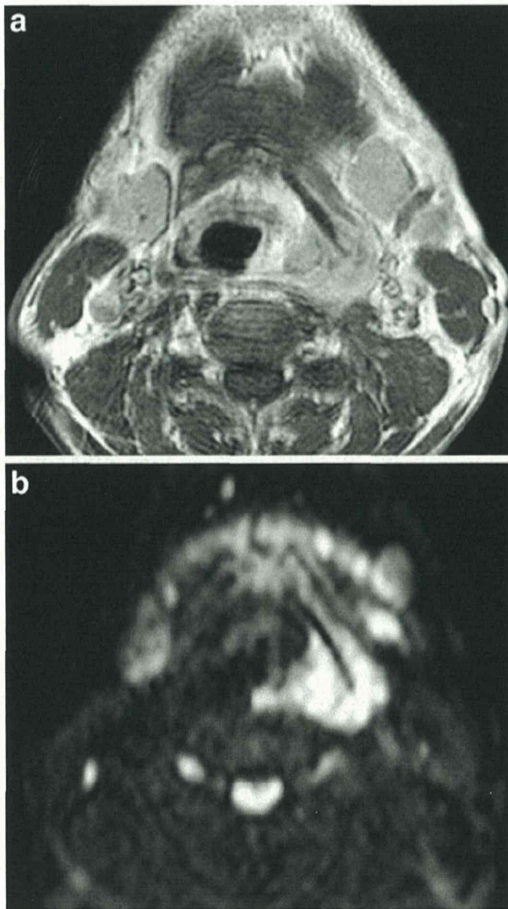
A representative poor-prognosis man in his 50s (local and regional failure at 3.3 months follow-up and died at 13.1 months follow-up) with hypopharyngeal cancer (T4N2M0, performance status 0, ADC 0–200 = $1.65 \times 10^{-3} \text{ mm}^2/\text{s}$, ADC 300–1,000 = $0.90 \times 10^{-3} \text{ mm}^2/\text{s}$). a Gadolinium-enhanced T1-weighted transverse image. b DW transverse image ($b = 1,000 \text{ s/mm}^2$)
